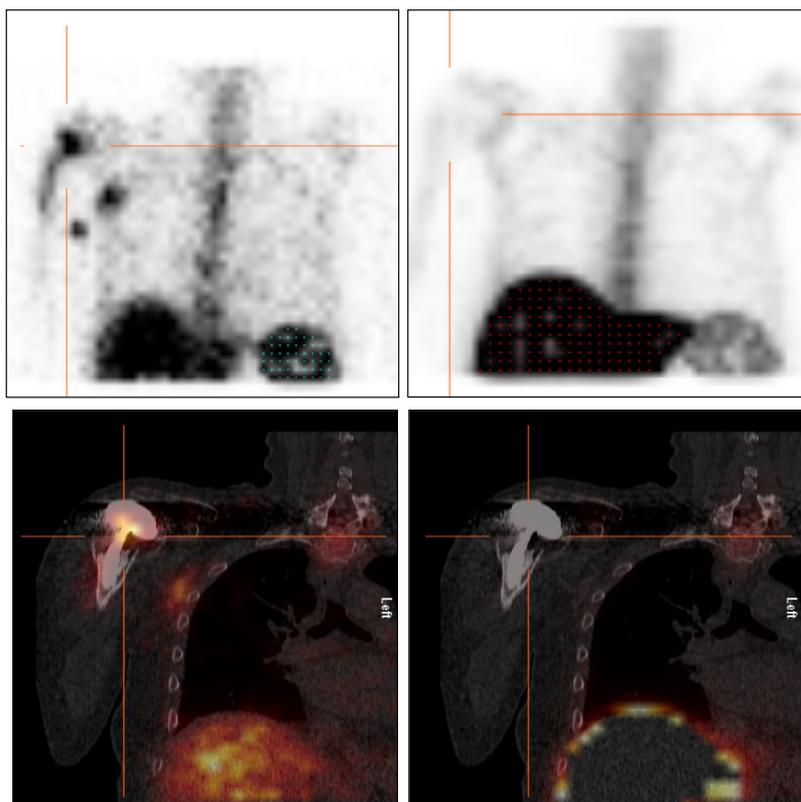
Example of a positive WBC/BM SPECT CT scan.
